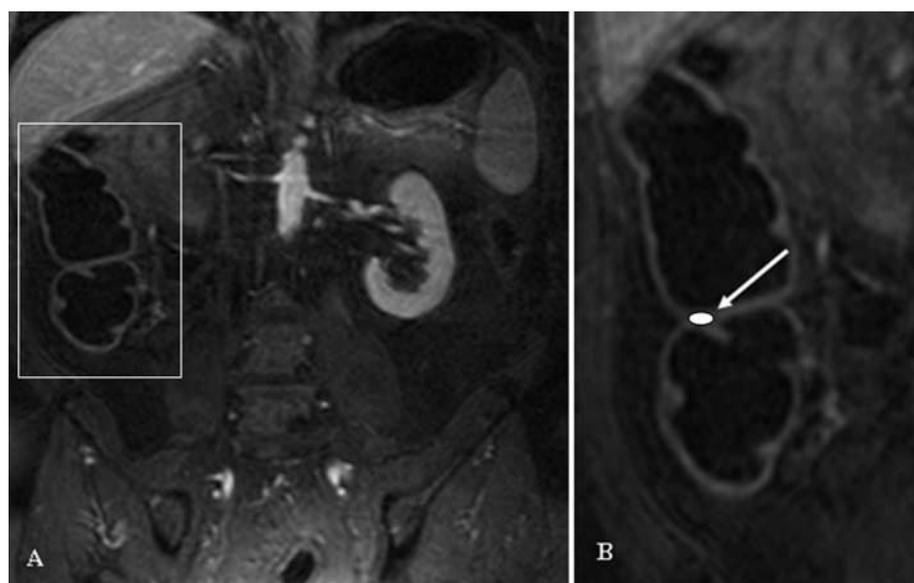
Coronal source image from T1-weighted gradient-echo 3D MR imaging data set A using a standard VIBE sequence (TR/TE 3.1/1.1 msec, flip angle 12°, matrix 168 × 256). The coronal source image was acquired after i.v. application of contrast medium. B is an enlargement of A. Contrast-to-noise ratio (CNR) in the wall of all colonic segments can be easily determined (circle and arrow).
